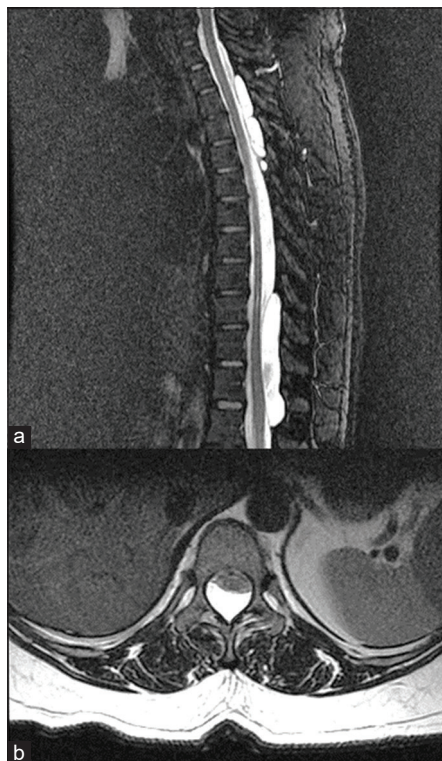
Preoperative imaging. (a) Mid-sagittal T2WI with fat suppression magnetic resonance imaging (MRI) demonstrating multiple (4) extradural spinal arachnoid cysts at T3-T5 and T10-L1 levels. (b) Axial T2 MRI demonstrating the surgically approached cyst at the T11 level, with spinal cord compression.
